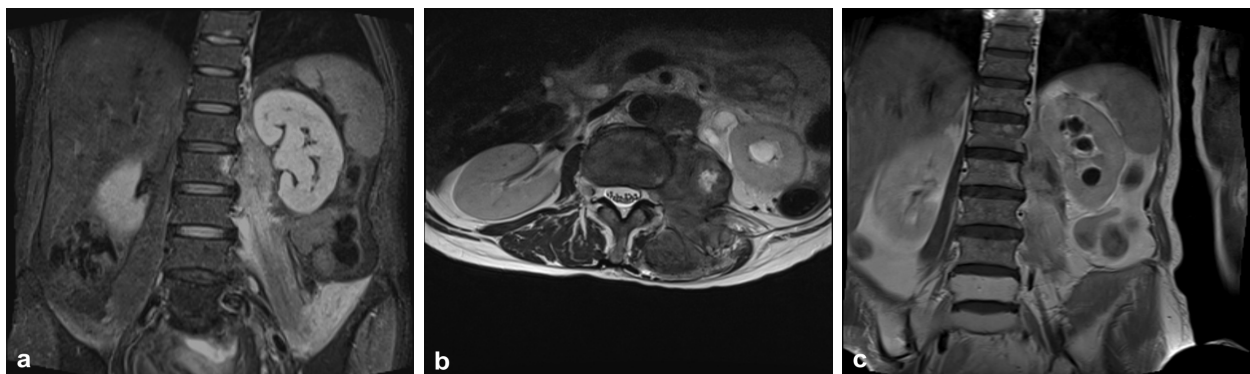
MRI examination: (a) Coronal plane section T2-STIR-weighted – high signal of the left iliac and psoas muscle, left hydronephrosis; (b) Axial plane section T2 weighted – extension of the tumor process in the lumbar square muscle, the longissimus dorsi muscle; (c) Coronal plane section, T1 weighted with contrast: heterogeneous enhancement capture of the left psoas muscle.
